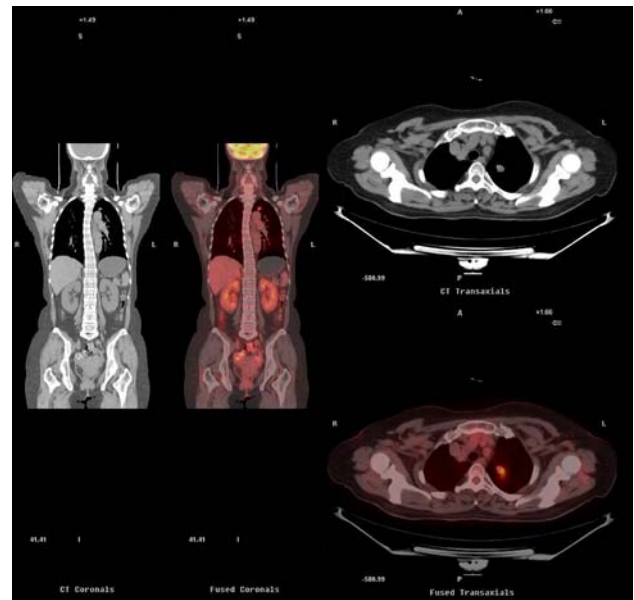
^{18}F -FDG PET/CT images of case two patient. Coronal images (*left*) and transaxial images of mediastinum window (*right*), CT images and PET/CT fused images. A round mass was located in the upper lobe of left lung, which was 1.5 cm in diameter. The intense FDG uptake was 6.4 in early imaging and 10.6 in late imaging
